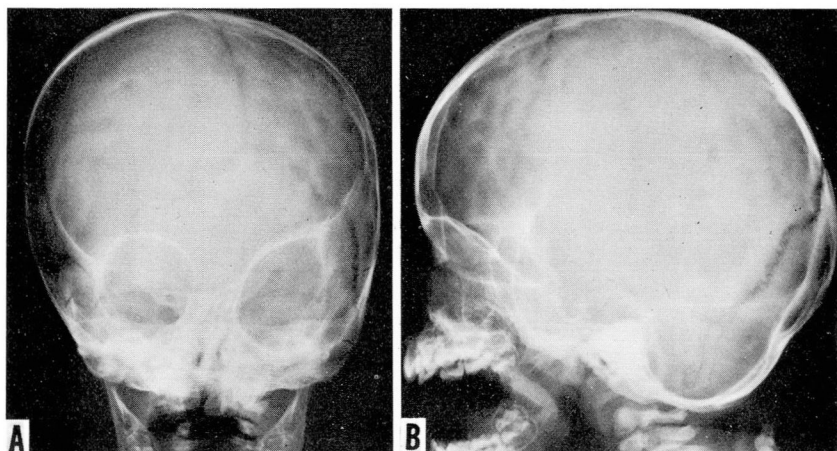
Case 1. Preoperative roentgenograms: A, the elliptic left orbit and slanted nasal septum are visible, also the elevation of the ipsilateral sphenoid ridge and the flattening of the parietal region. B, only the uninvolvement of the coronal suture can be seen.
